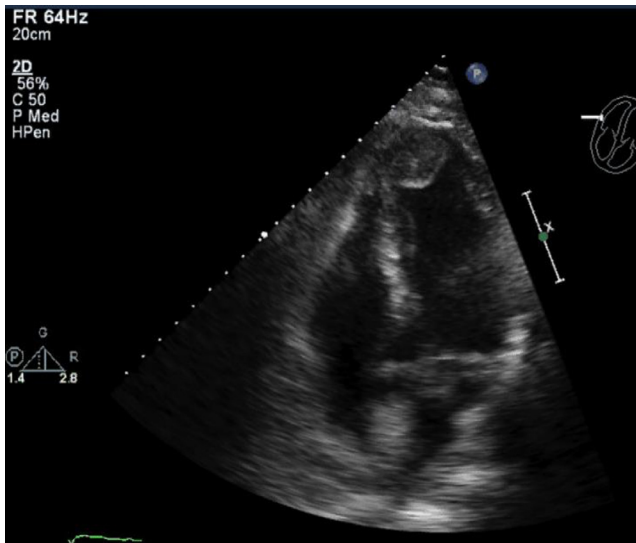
Apical four-chamber transthoracic echocardiogram demonstrating apical thrombus.
